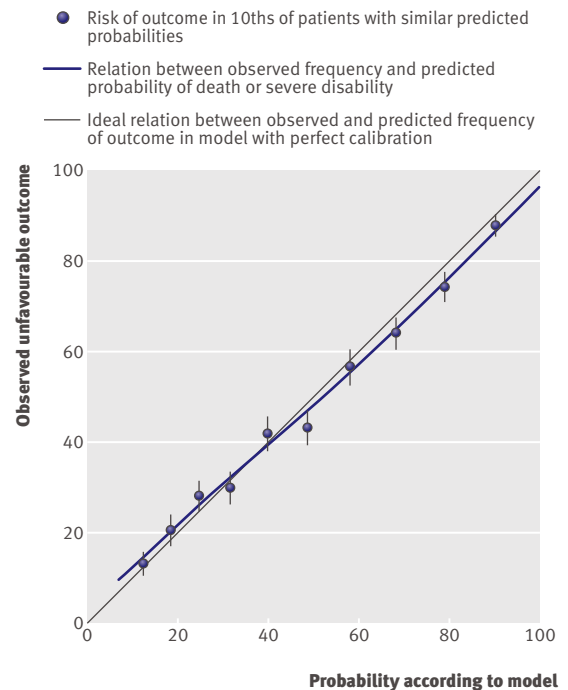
External validation of CT model for death or severe disability at six months in IMPACT database
